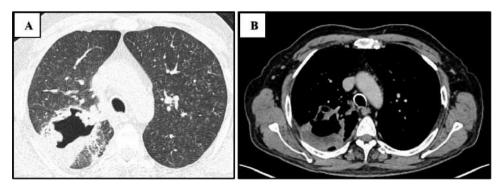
(A – Lung Window, B – Mediastinal Window): FDG avid (SUVmax- 4.7) irregularly marginated thick-walled (1.6 cm) cavitary lesion in the right lung upper lobe, measuring approximately  $6.2 \times 4.4$  cm in size.
